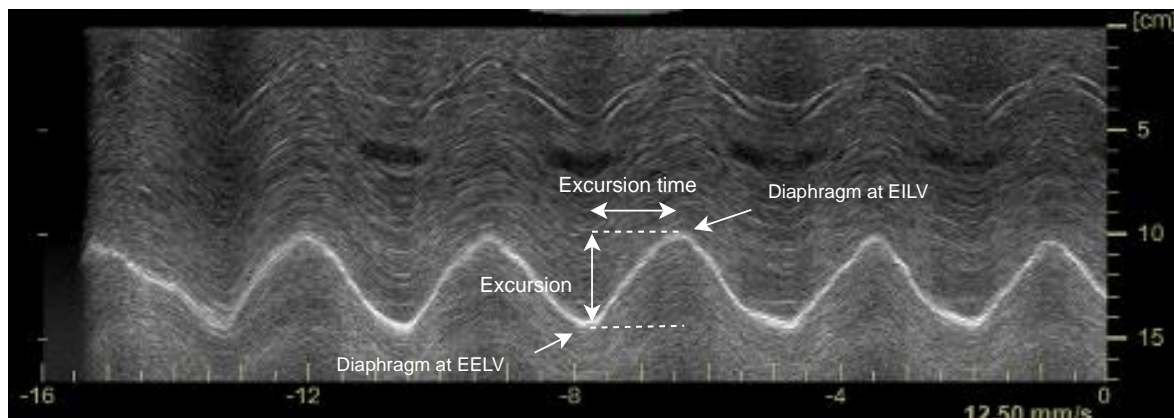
M-mode ultrasound of crural diaphragm excursion during hypercapnic hyperpnoea. Diaphragm excursion and excursion time were measured as shown by white arrows. X-axis represents time (s) and y-axis represents distance (cm) from transducer. This cine-loop was recorded in a male participant at  $\dot{V}_I$  19.6 L/min and  $V_{TI}$  1.7 L, with diaphragm excursion measuring  $4.8 \pm 0.2$  cm and excursion velocity of  $2.6 \pm 0.3$  cm/s.
